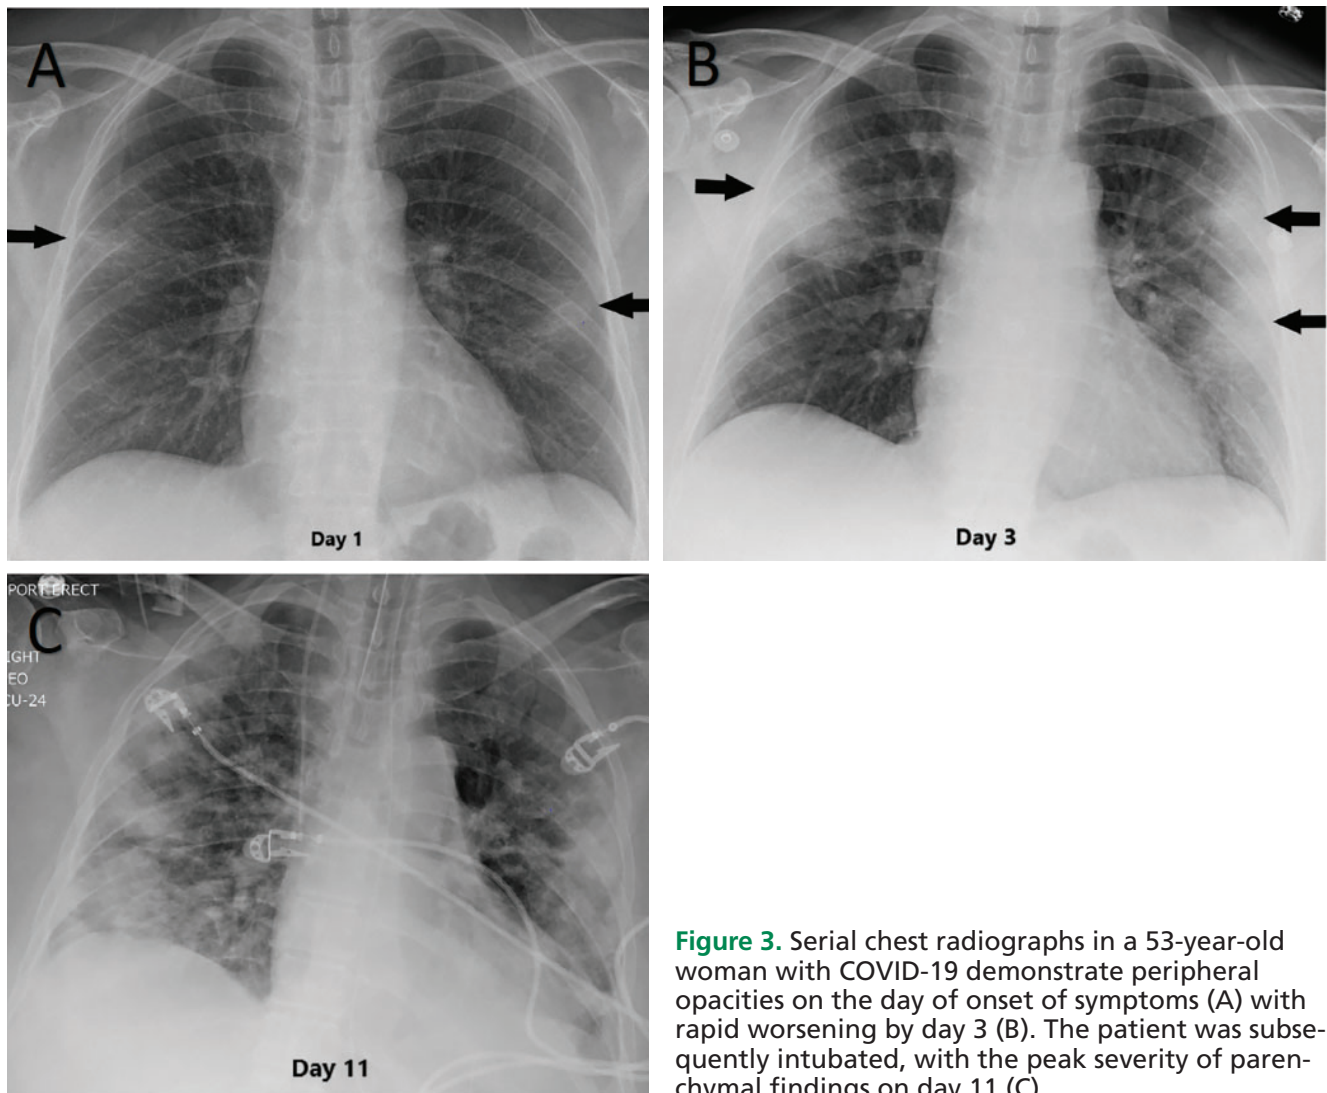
Serial chest radiographs in a 53-year-old woman with COVID-19 demonstrate peripheral opacities on the day of onset of symptoms (A) with rapid worsening by day 3 (B). The patient was subsequently intubated, with the peak severity of parenchymal findings on day 11 (C).
